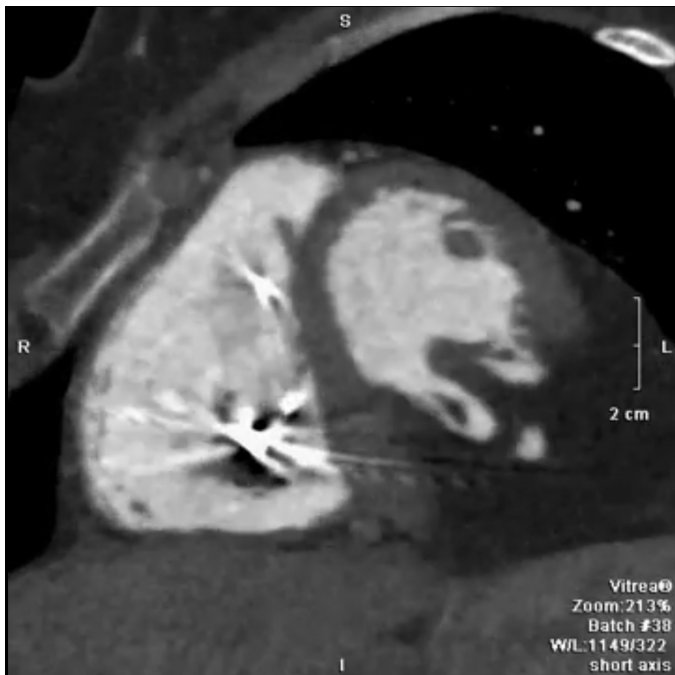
CT scan of the heart of 27 years old patient, performed a week after the Cesarean section in 2019. The short axis of the CT scan of the heart shows a contrast leak into the giant tumor of the LV. Implantable cardioverter-defibrillator diverted to the RV
